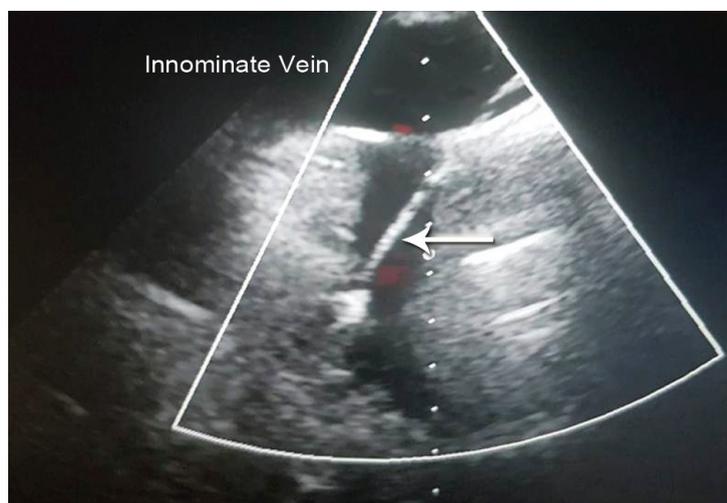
The image depicts transthoracic echocardiography in the suprasternal view. The arrow demonstrates the abnormal drainage of a vertical vein into the innominate vein.
